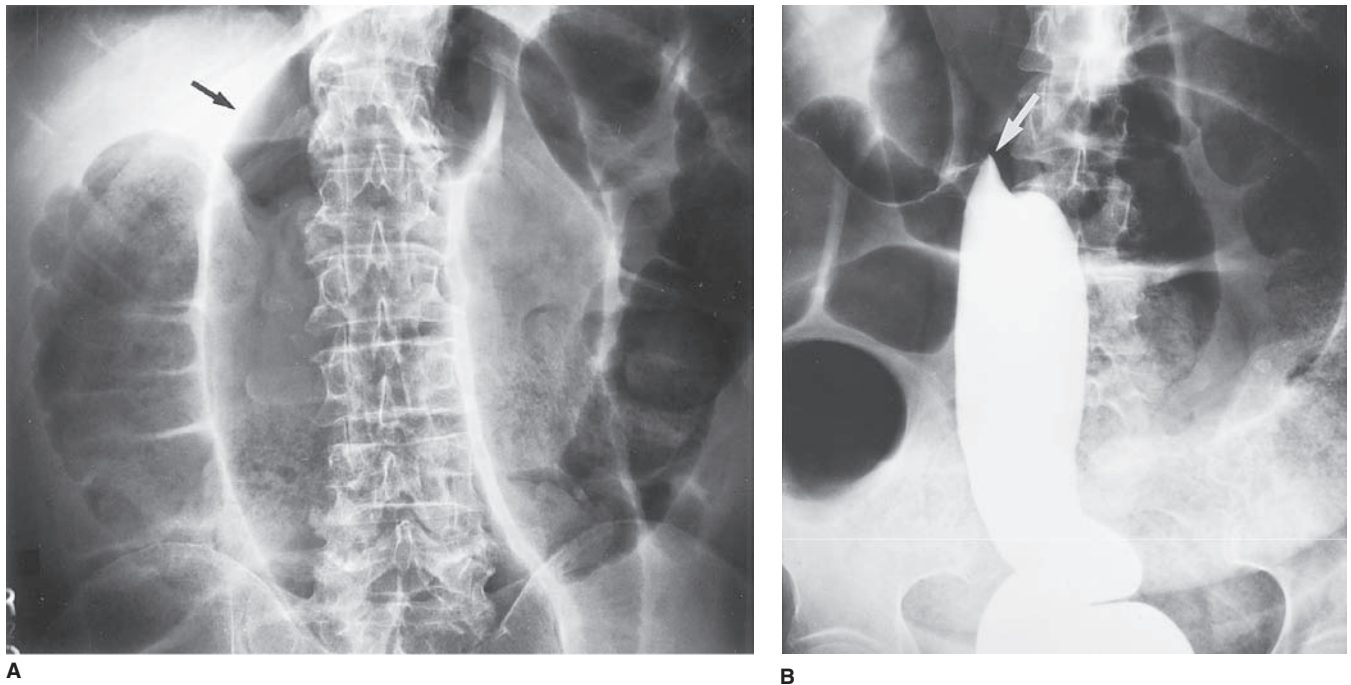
Sigmoid volvulus. A. Supine abdominal radiograph showing the dilated, volvulated segment of redundant sigmoid colon pointing toward the right upper quadrant; *arrows* show the space between the sigmoid and hepatic and splenic flexures. B. Contrast enema in sigmoid volvulus showing cutoff at distal site of volvulated sigmoid having a “bird-beak” appearance.
